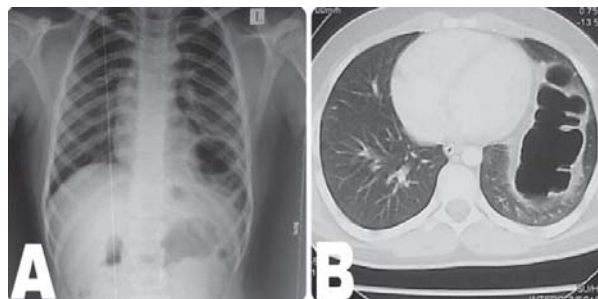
(a) The chest X-ray shows non-visualization of left diaphragm and presence of distended bowel loops; (b) Axial post-IV contrast CT through the lower chest showing herniated bowel loops in the left lung field.
